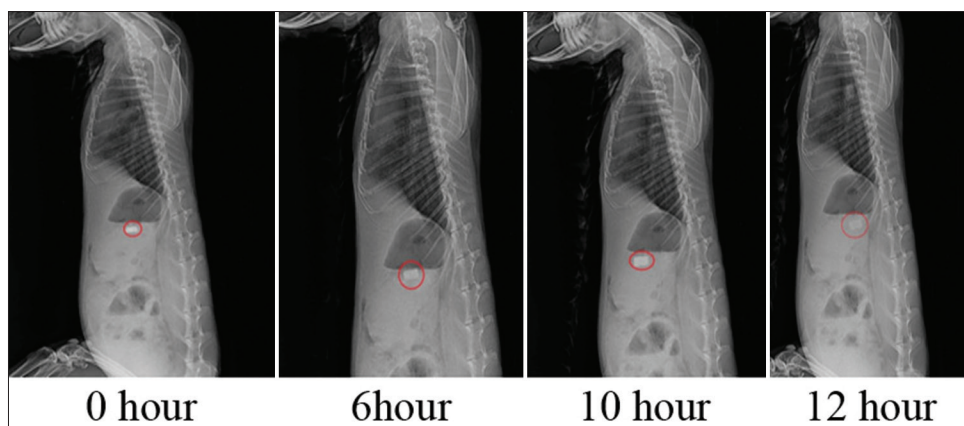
In vivo* X-ray studies of floating of optimized formulation F1
